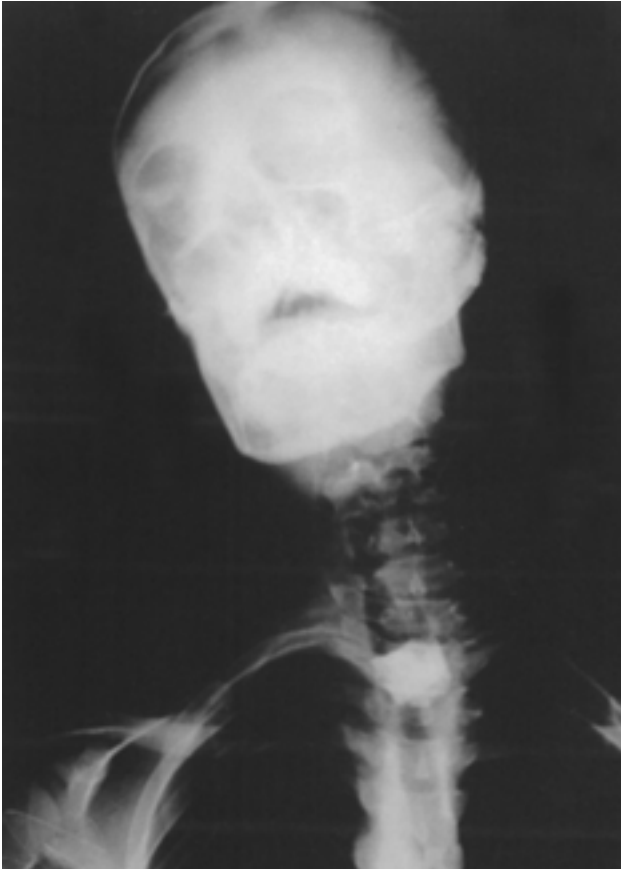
Postero-anterior cervical radiograph
